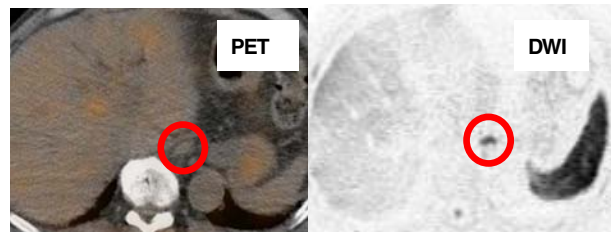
The case that was detected lymph node by DWI only. (81y.o., male, pancreatic carcinoma)
